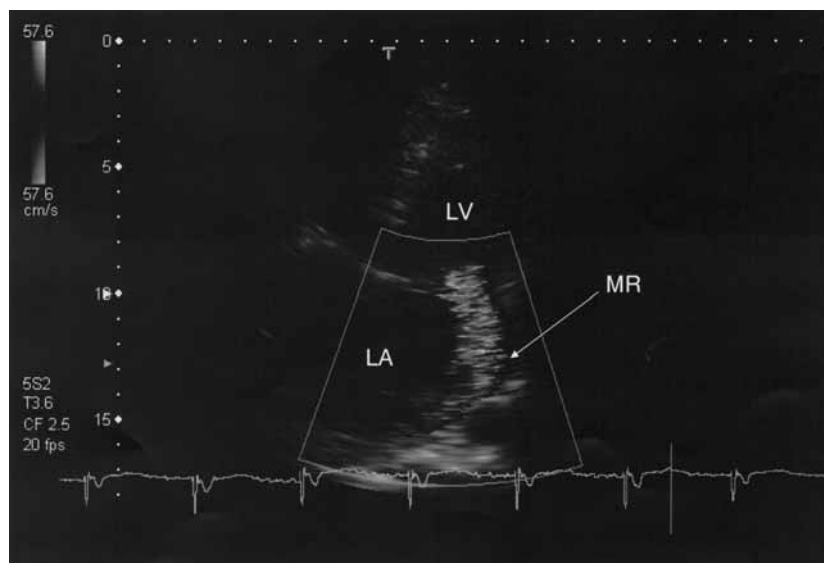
Pre-operative echocardiography showing MR. MR was detected by echocardiography. The grade was “severe” by determination of the jet distance, but the width of the regurgitant jet was relatively narrow. The anterior mitral leaflet was slightly prolapsed. LA, left atrium; LV, left ventricle; MR, mitral regurgitation.
